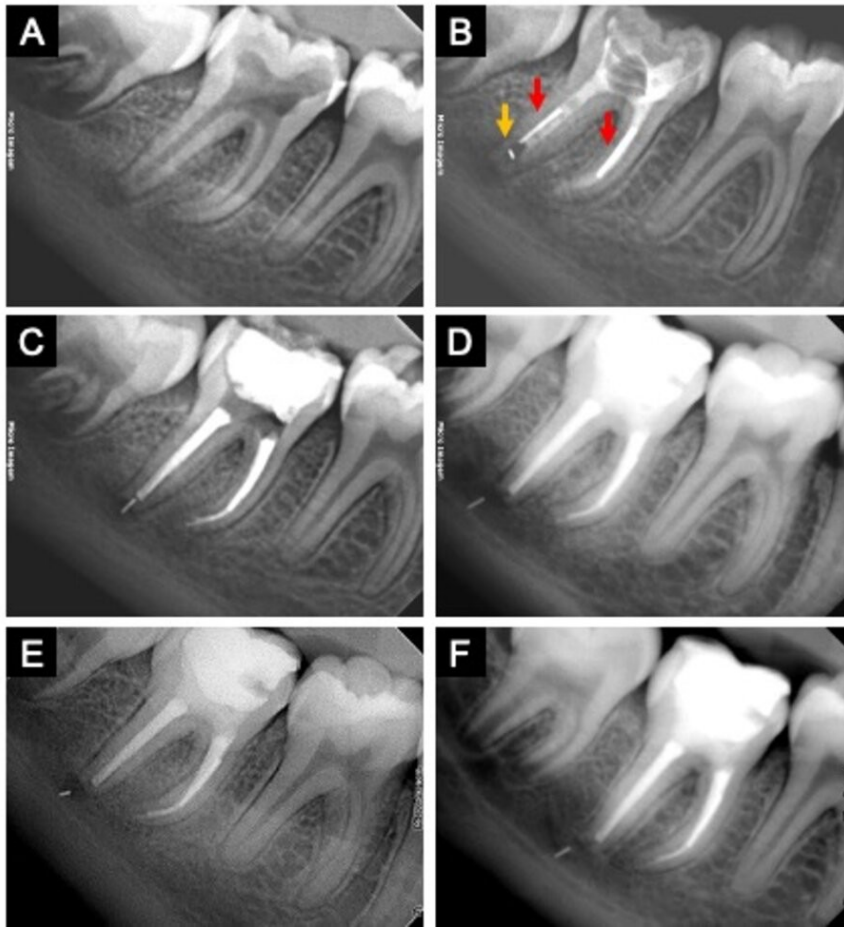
Radiographic images of case 2: A) Preoperative radiograph of the right mandibular second molar (tooth 47) showing periapical radiolucent lesion; B) Radiograph after biomechanical instrumentation showing a fragment of the XP-Clean instrument (yellow arrow) within the distal canal and fragments of ultrasonic inserts (red arrows) within the mesiobuccal and distal canals; C) Radiograph after endodontic root canal filling; D) 6-month follow-up; E) 12-month follow-up; F) 18-month follow-up showing bone repair in the periradicular area.
